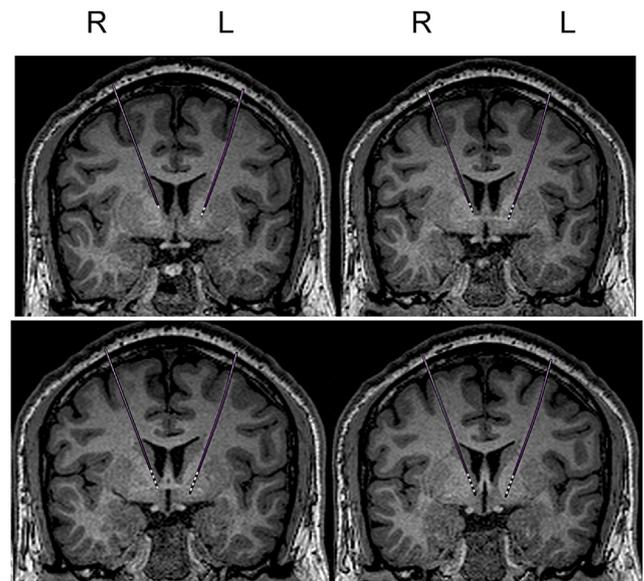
MRI with deep brain stimulator leads overlaid. The left lead traverses the anterior limb of the internal capsule with the majority of contacts aligned A-P with the anterior commissure. The right lead is more medial but still within capsule, traversing the caudate nucleus before reaching the capsule.
